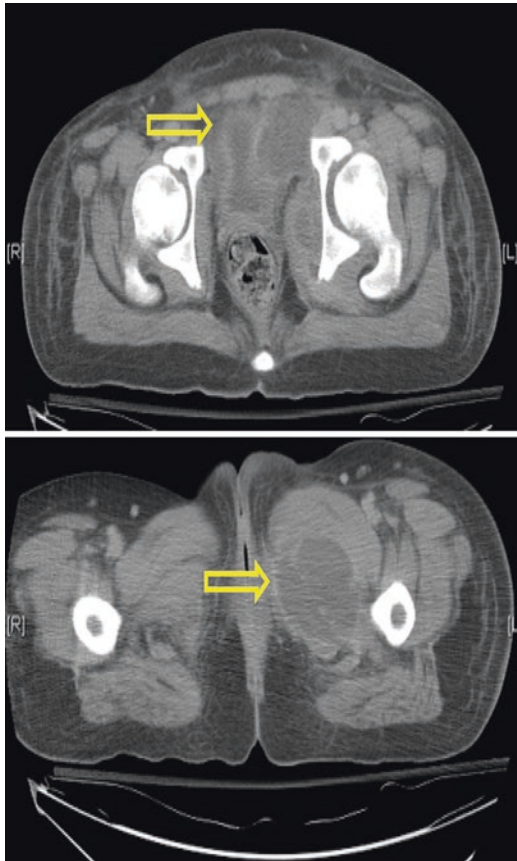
A computed tomography of thighs demonstrated pyomyositis of left adductor magnus (arrow)
